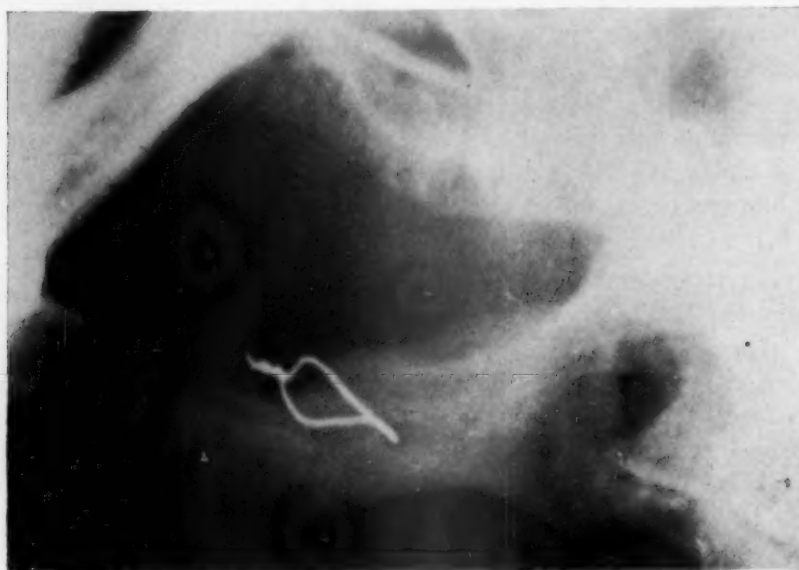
X-ray showing intraoral wiring employed for fixation of fracture. The mandibular canal emerges on the surface of the alveolar ridge under the wire.
